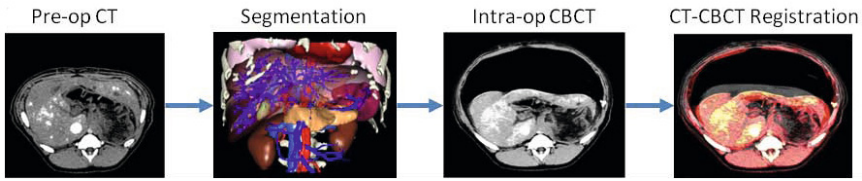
Registration of pre-operative CT to intra-operative CBCT
